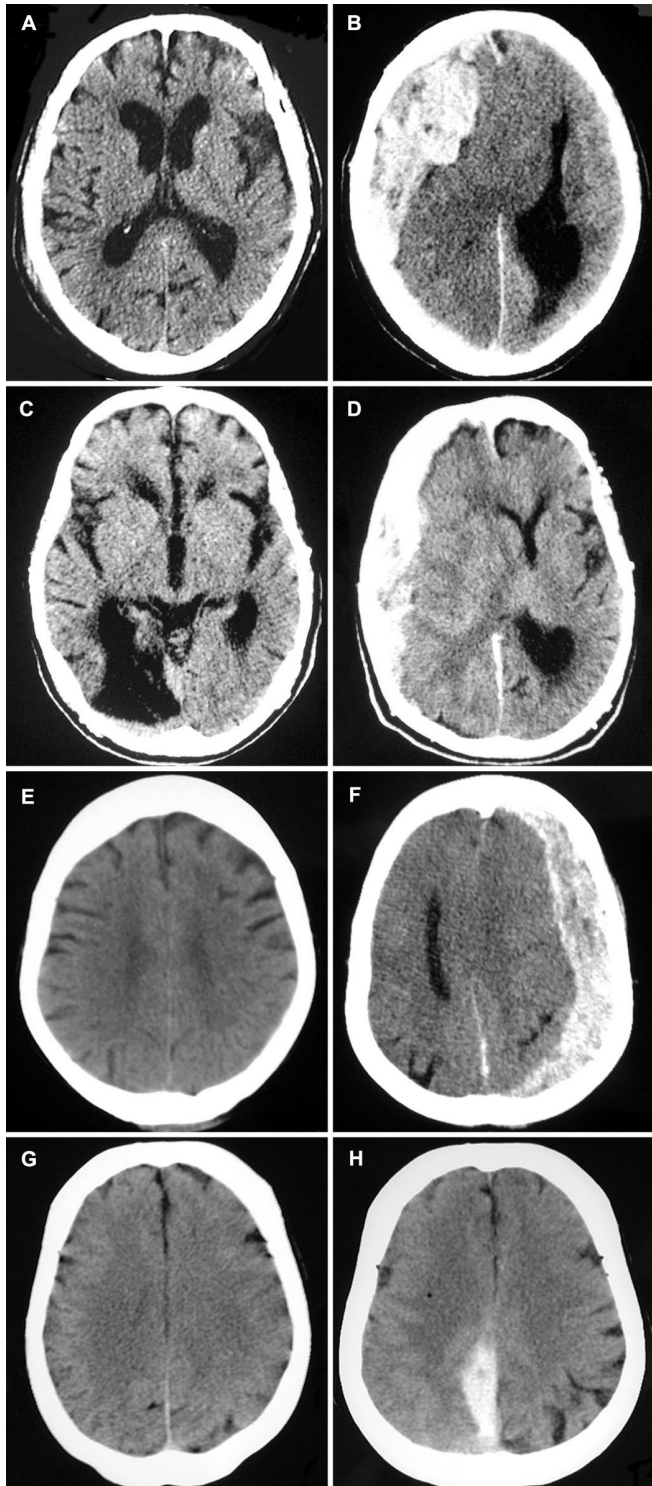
A, head CT scan in an 86-year-old man (Patient 1) obtained 6.5 hours after mild TBI revealing moderate brain atrophy. B, head CT scan in the same patient, performed after abrupt neurological deterioration 3 days after trauma, revealing a large right acute subdural hematoma with mass effect. C, head CT scan in a 69-year-old man (Patient 2), obtained in the emergency department approximately 3 hours after a fall in the nursing home where the patient resided, revealing an old infarction in the right occipital region and generalized atrophy. D, repeat head CT scan, performed 12 hours after the initial fall owing to a sudden deterioration in the patient's consciousness, with obvious left-sided weakness, revealed a large right side acute subdural hematoma with mass effect and consequent subfalcine herniation. E, initial posttrauma head CT scan in a 65-year-old woman (Patient 3). F, 1 day after her mild TBI, the patient was found unconscious at her home. At readmission, she had right hemiplegia and her left pupil was fixed and dilated. Head CT scanning revealed a large acute subdural hematoma. G, normal head CT scan upon admission in a 72-year-old woman (Patient 4) who was assaulted when her home was burglarized. H, a second CT scan, obtained 1 day later, after the patient developed left leg plegia, revealing acute interhemispheric subdural hematoma.
